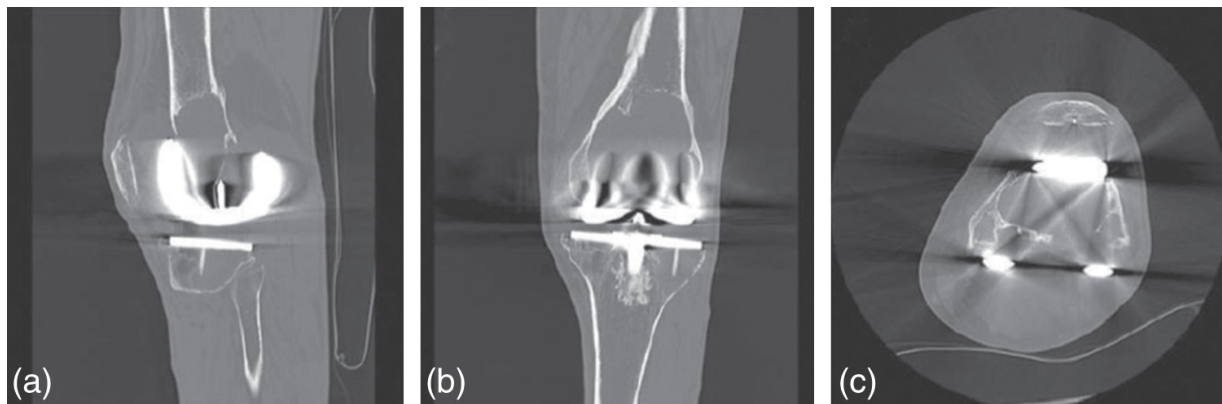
CT scan showing femoral bone loss due to osteolysis on cross-sectional imaging in the same 69-year-old patient. Representative (a) sagittal, (b) coronal, and (c) axial images showing degree of bone loss.
